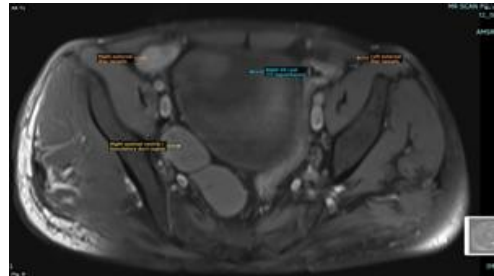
Axial T1 MRI pelvis: The right SV cyst is T1-hypointense (simple fluid, no haemorrhage). The right seminal vesicle and ejaculatory duct region are labelled, where obstruction of the ejaculatory duct — the third arm of the triad — was confirmed. Bilateral external iliac vessels serve as anatomical landmarks.
